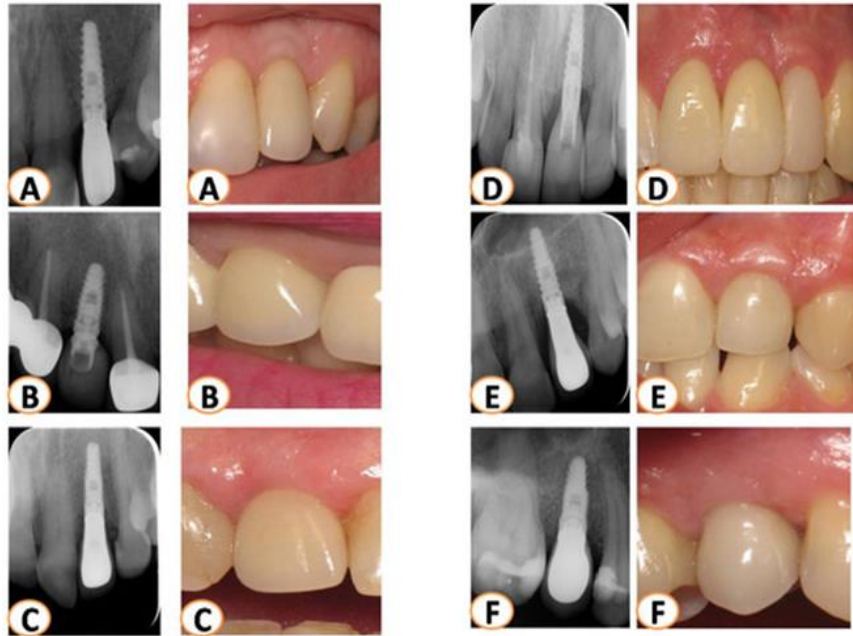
Representative long-term follow-ups (≥ 7 years) using radiographs and photographs (cases A–F).
